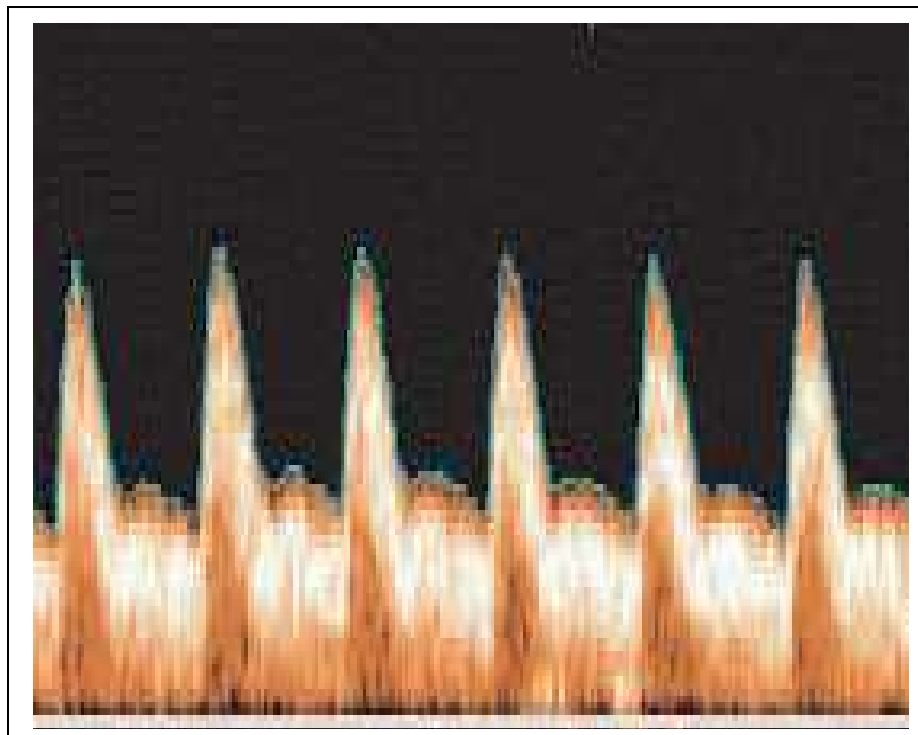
Normal color Doppler waveform of the uterine artery at 24 weeks.
